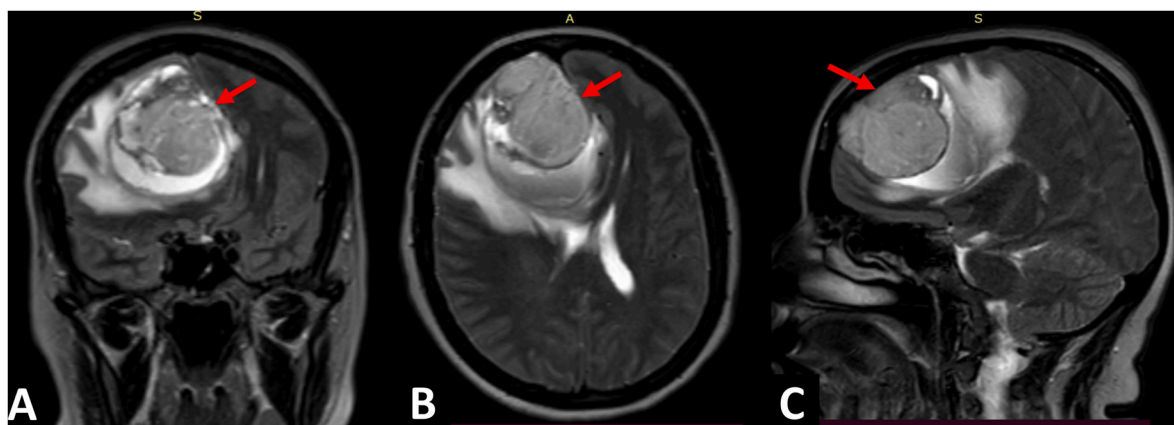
T2-Weighted MRI showing a giant meningioma centered in the anterior fossa with severe perilesional edema, 20 mm midline shift, ventricular compression and radiological signs of severe intracranial hypertension.
